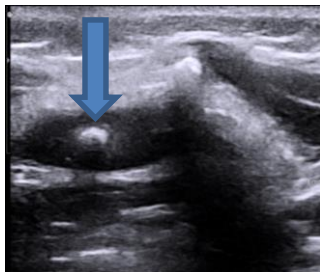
Ultrasound image depicting prominent filum terminale (Arrow) encountered during caudal epidural catheter placement.
